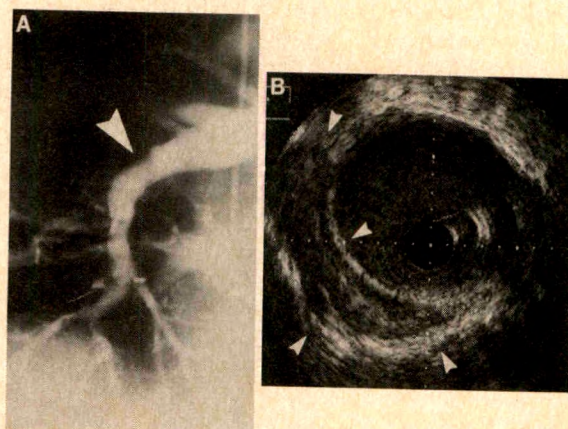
A*, angiographic image of the right pulmonary artery showing a tapering of the intermediate branch (arrow). *B*, intravascular ultrasound image of the intermediate pulmonary artery showing an echolucent mass adjacent to the vessel wall (small arrows) (2 mm between dots). At operation, a fibrous histiocytoma was found.
